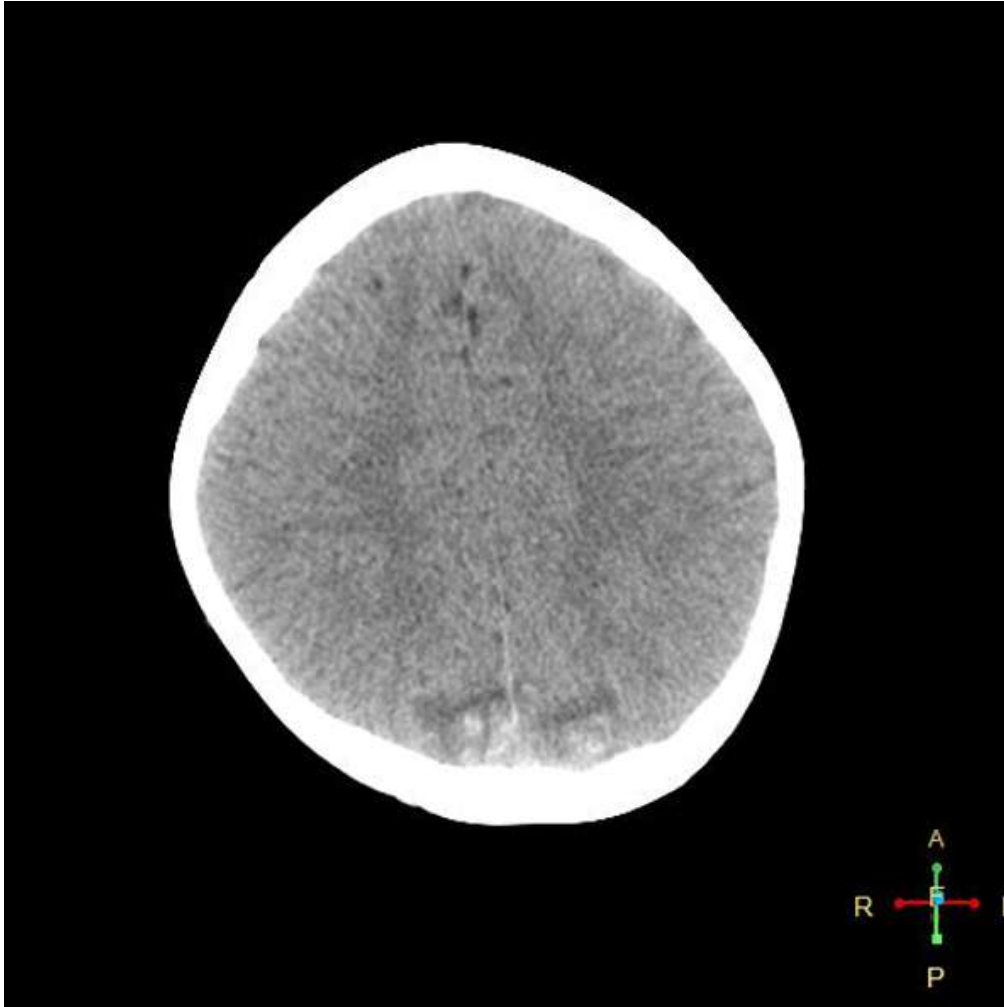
CT demonstrating bilateral hemorrhagic cerebral contusions in the posterior parietal lobes opposite to the site of trauma. Case courtesy of Heba Abdelmonem, Radiopaedia.org, rID: 48869
